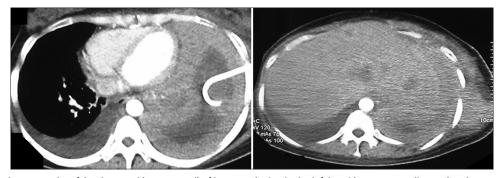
Computed tomography of the thorax with contrast: (Left) a mass lesion in the left hemithorax, extending to the chest wall and mediastinum with bilateral pleural effusion and left pleural thickening. (Right) multiple metastatic nodules in the liver
